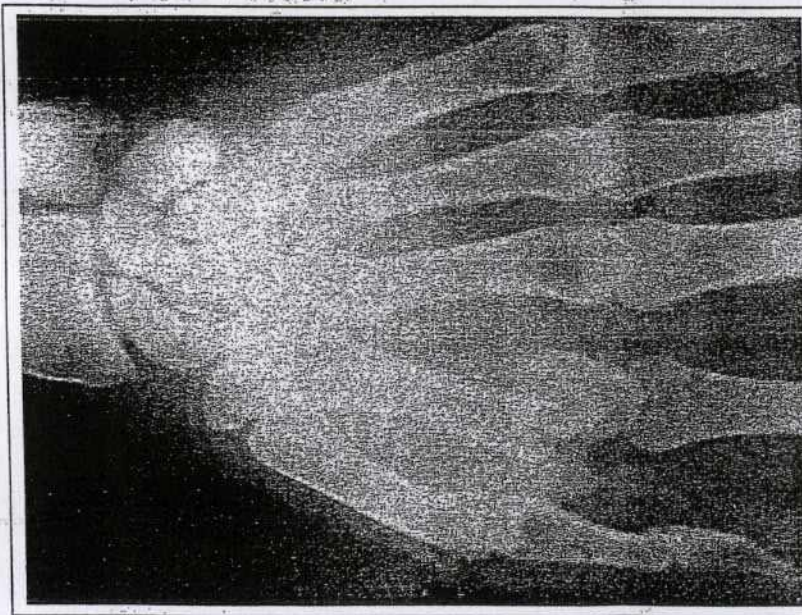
Pre-operative X-ray showing trapezium fracture.
